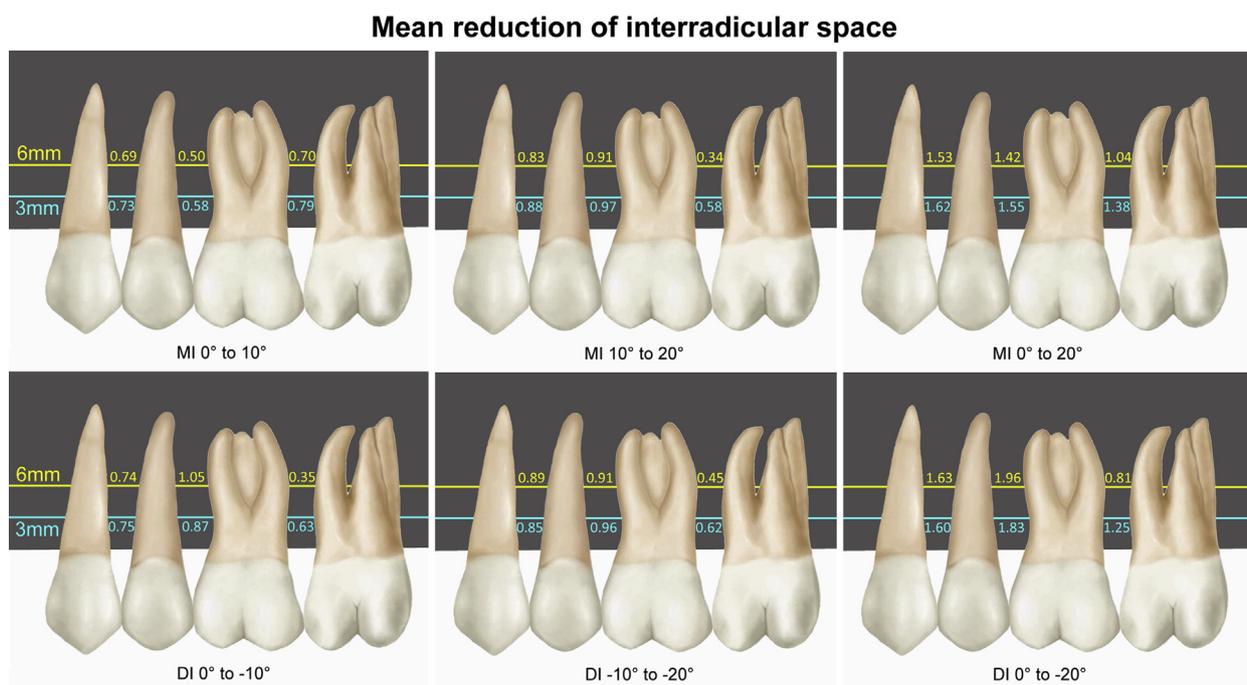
Mean reduction of interradicular spaces produced by mesial and distal angulation of the x-ray beam.
